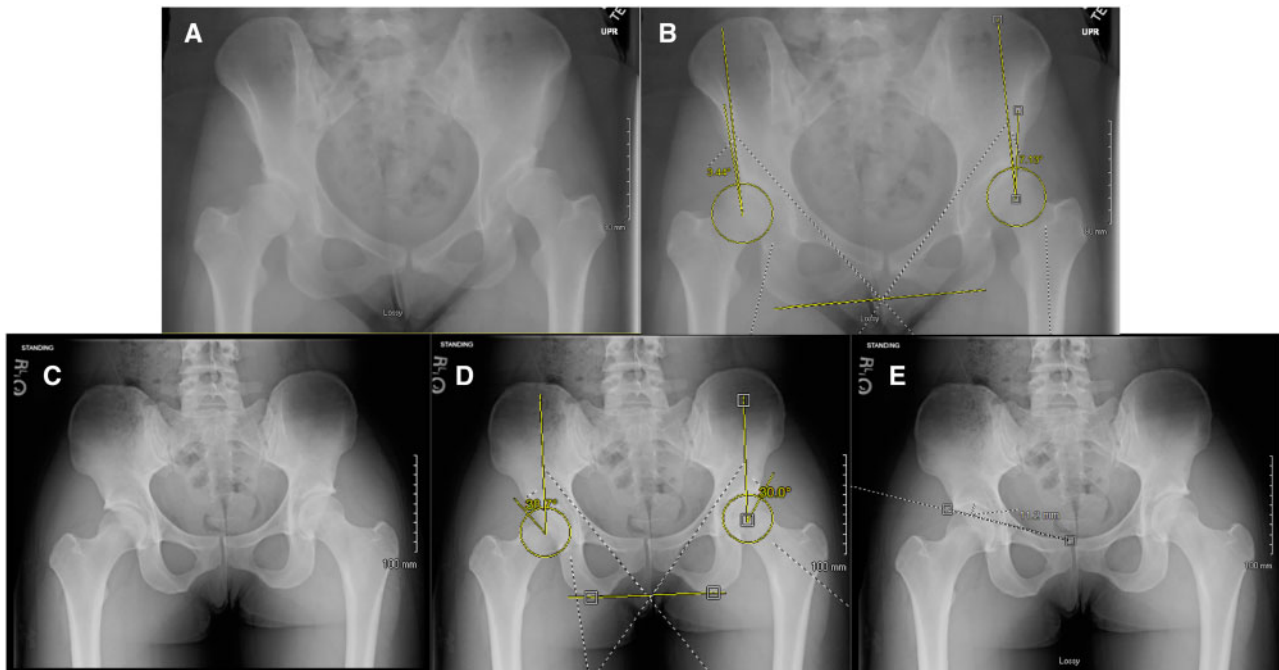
Standing AP pelvis radiographs of (A) patient with radiographic diagnosis of left hip dysplasia (B) with bilateral LCEA $< 25^\circ$ and (C) patient with no radiographic diagnosis of hip dysplasia (D) with bilateral LCEA $> 25^\circ$. (E) Demonstrates the acetabular depth measurement (Table II) in which a line is drawn from the superior edge of the pubic symphysis to the edge of the acetabular roof. A perpendicular line is drawn to the deepest portion of the acetabular roof. Measurements < 9 mm are thought to represent decreased acetabular coverage [12, 13].
